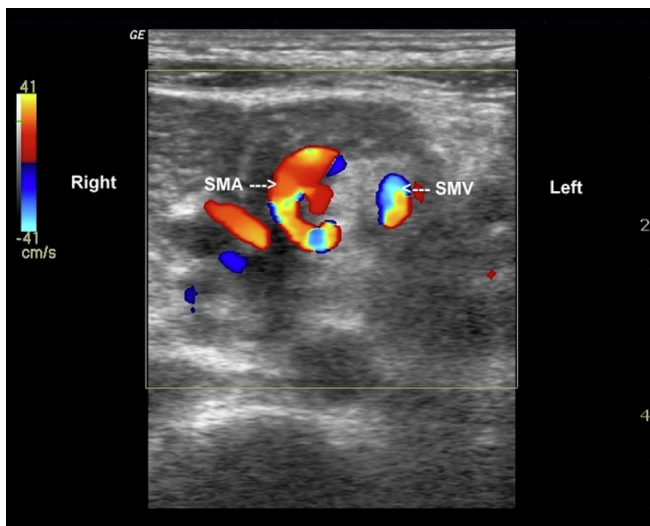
US with midgut volvulus. Grey scale and color Doppler US through the upper abdomen show whirling vessels and surrounding small bowel loops on transverse scan and corkscrew appearance on longitudinal scan. SMA-SMV relation is reversed. Case courtesy of KewalArunkumar Mistry, Radiopaedia.org, rID: 34790.
